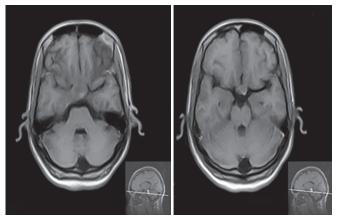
T1-weighted MRI image showing heterointense lesion
